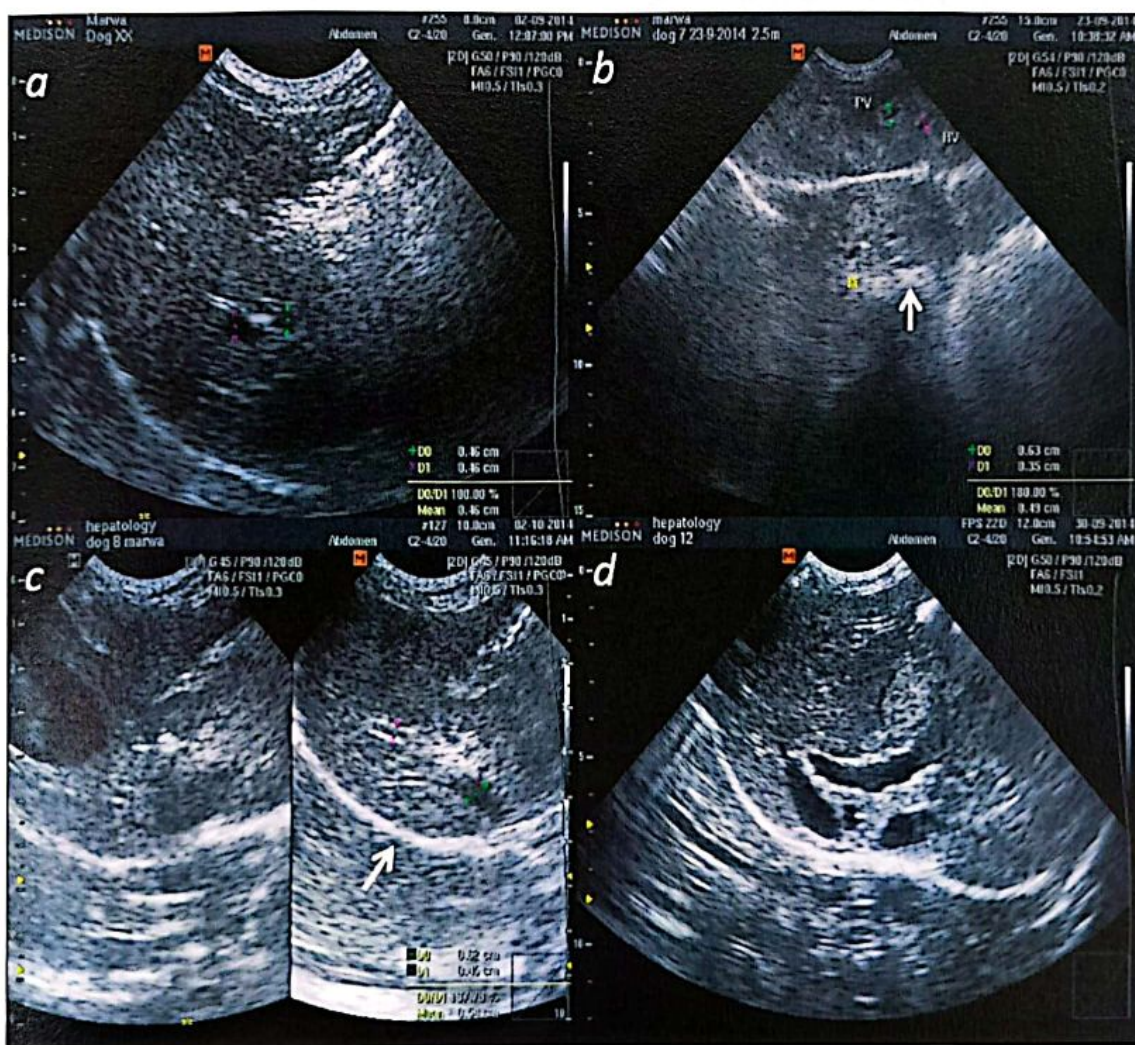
Two dimensional ultrasound scan at:
